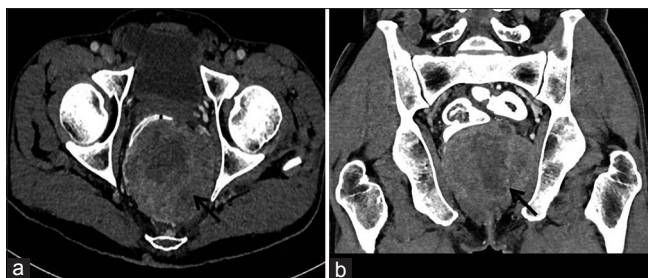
(a and b) Pretreatment imaging. Axial and coronal reformatted computed tomography images showing heterogeneously hyperenhancing exophytic mass lesion arising from rectum (arrows)
